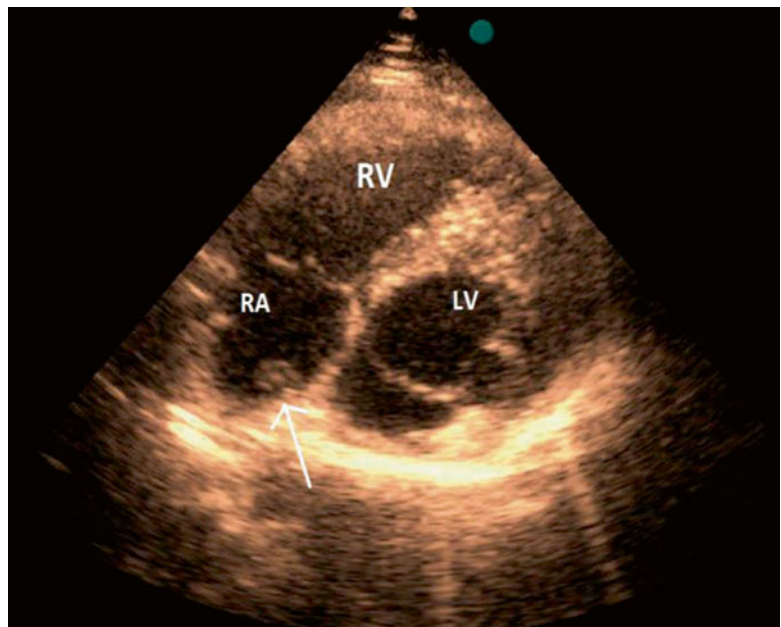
Postoperative echocardiography in an adult patient with atrial septal defect repair by pericardial patch, showing an echogenic mass attached to the right side of the interatrial septum, suggestive of thrombosis (arrow). RV right ventricle, RA right atrium, LV left ventricle
